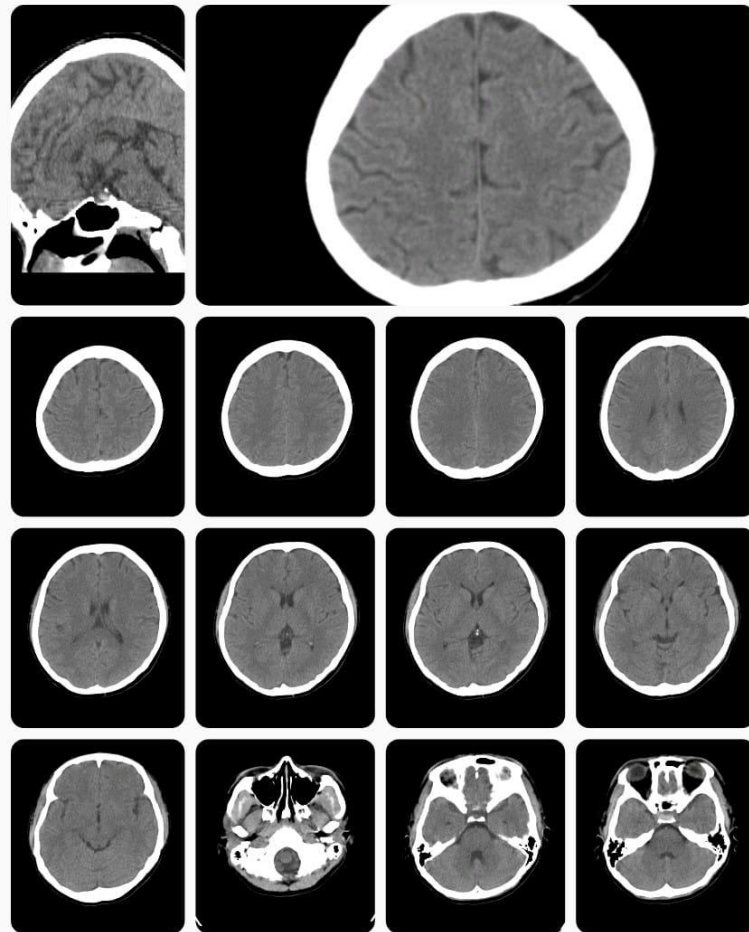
A CT-Scan examination of the head revealed no presence of any intracranial SOL or signs of increased intracranial pressure (ICP)
